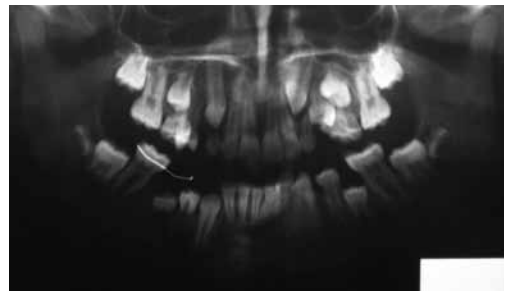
Panoramic Xray after 11 months, showing the premolars emerging during the eruption process; note the satisfactory bone healing.
